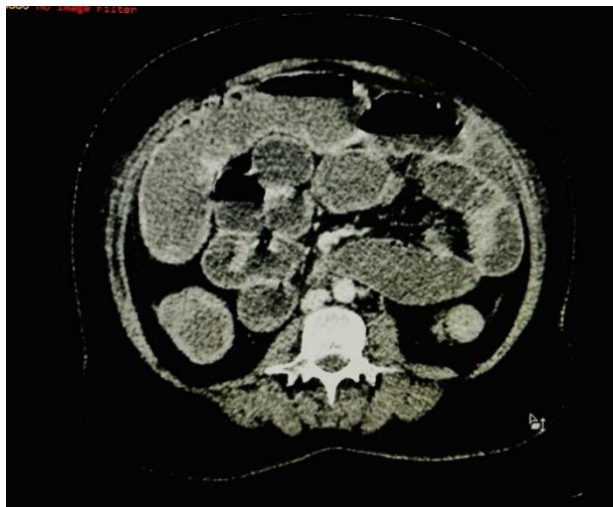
CT abdomen pelvis showing long segmental circumferential wall thickening of proximal part of descending colon causing near total luminal narrowing.
